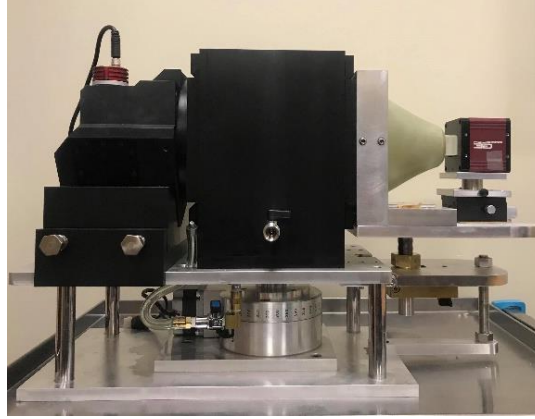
Photograph of the developed optical CT scanner.
